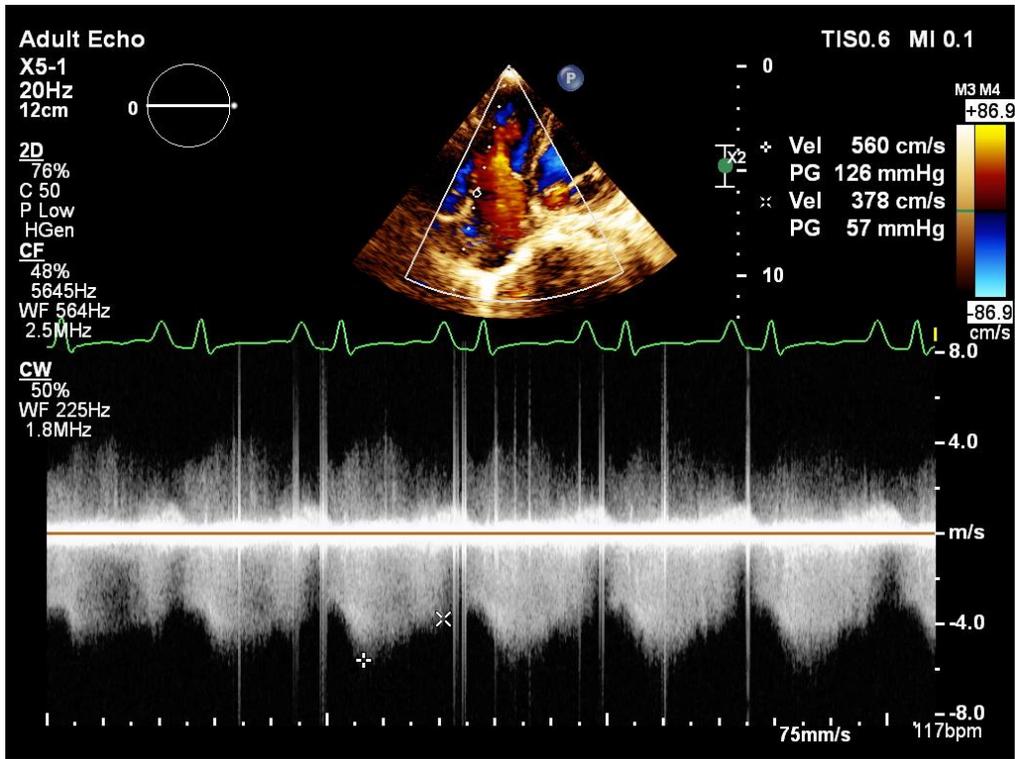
Doppler echocardiography showing a high-pressure gradient across the defect
